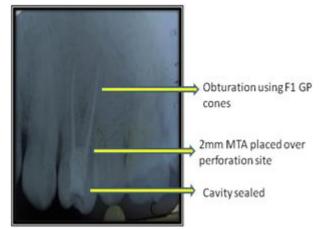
Post operative IOPA X-ray with 24
